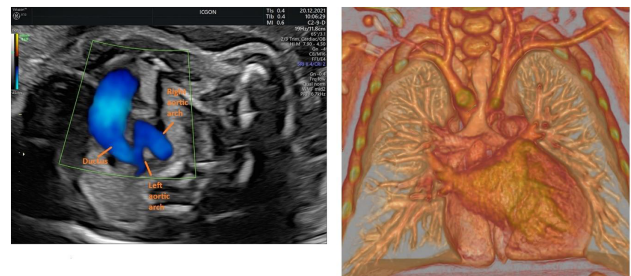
“Z sign” in fetal echo in a patient with DAA Figure 1B Computed Tomography Angiography showing tracheal compression in a patient with DAA
